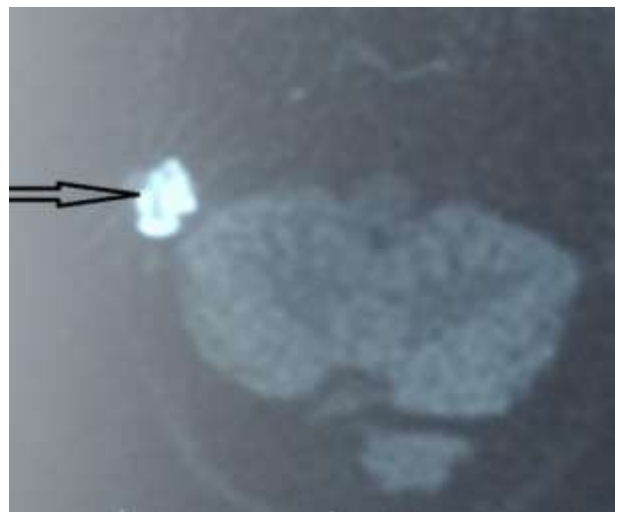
Non-EPI DWI: Hyperintense "bright spot" indicating recurrence
